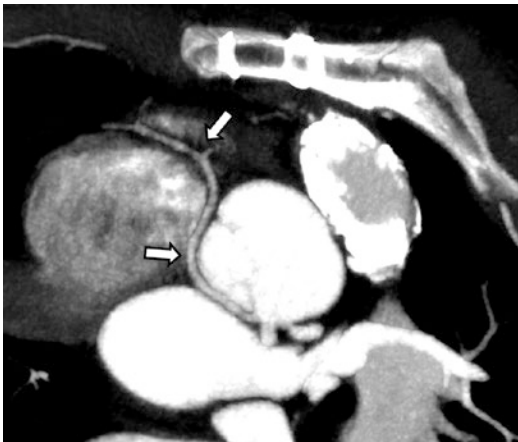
Same patient as in Fig. 8. CT angiography with maximum intensity projection (MIP) of the coronary arteries, demonstrating an aberrant course of the right coronary artery (arrows) arising from the left coronary sinus with retro-aortic course to the right atrioventricular groove. A retro-aortic course is benign
